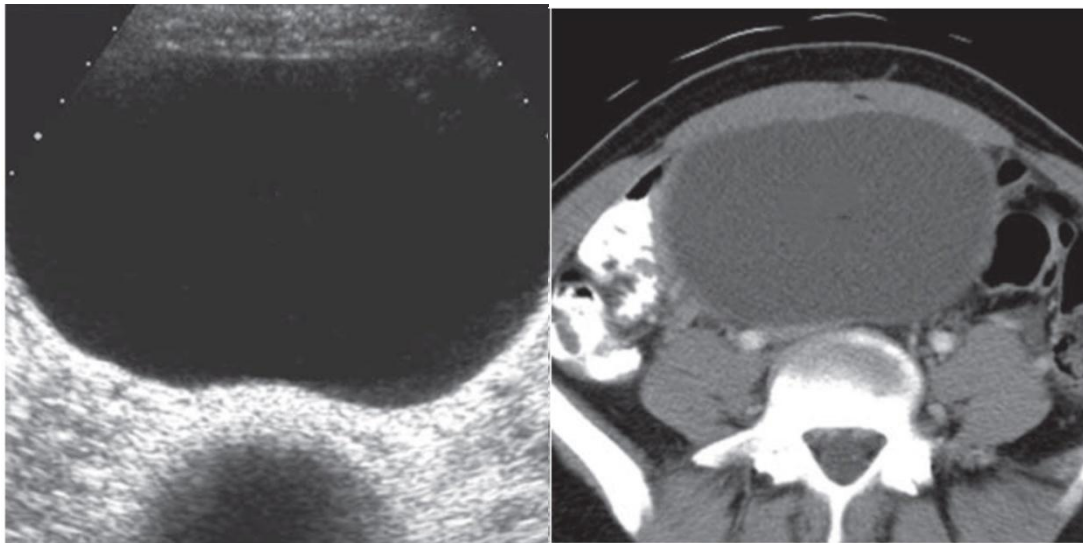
Mesenteric cyst Right, Transverse ultrasound image of midabdomen shows large anechoic cystic mass with imperceptible wall. Left, Contrast-enhanced axial CT image shows well-circumscribed cystic mass without enhancement in mid abdomen.
